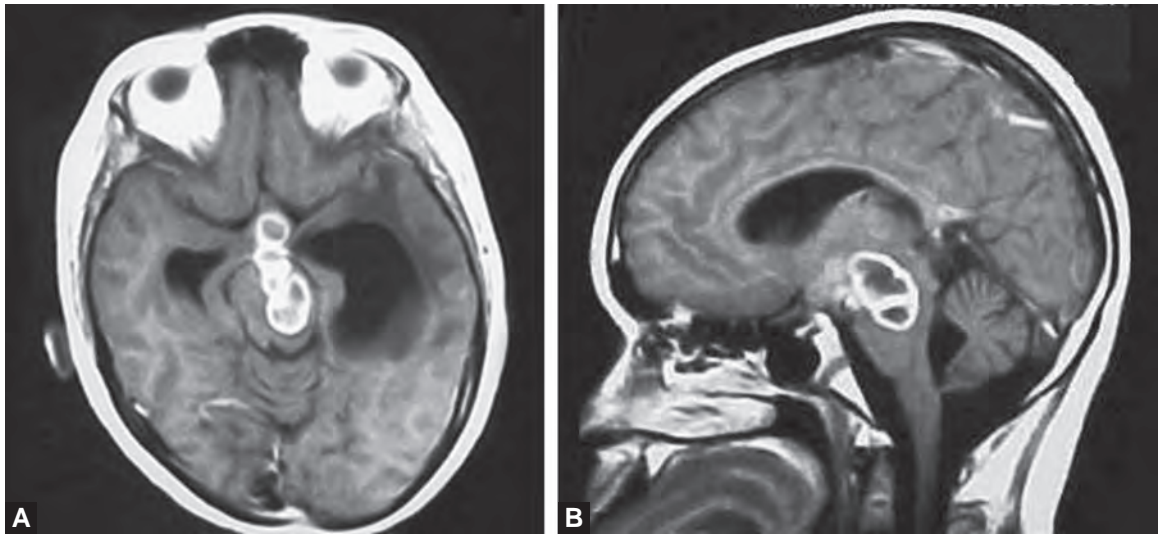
Contrast MRI of the brain showing infratentorial tuberculoma
